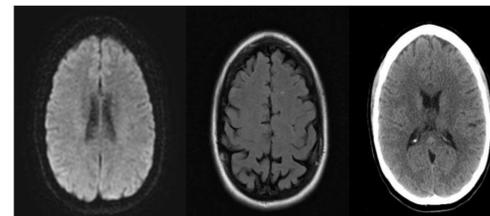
Diffusion weighted MRI with no evidence of intracranial abnormality; Figure 2. T2/FLAIR MRI with non-specific punctate hyperintensity in left frontal lobe; Figure 3. CT head with out evidence of hemorrhage, stenosis, occlusion or aneurysm (CT angiogram not shown).
